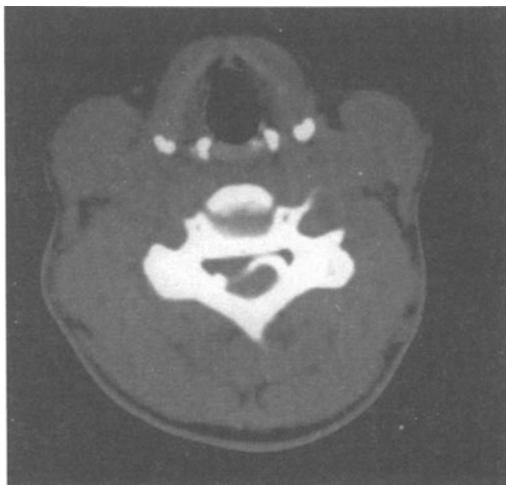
Cervical Disc Rupture: Brown Sequard Syndrome, Case History # 9-1: CT Scan of cervical cord post metrizamide myelography. Refer to text.
